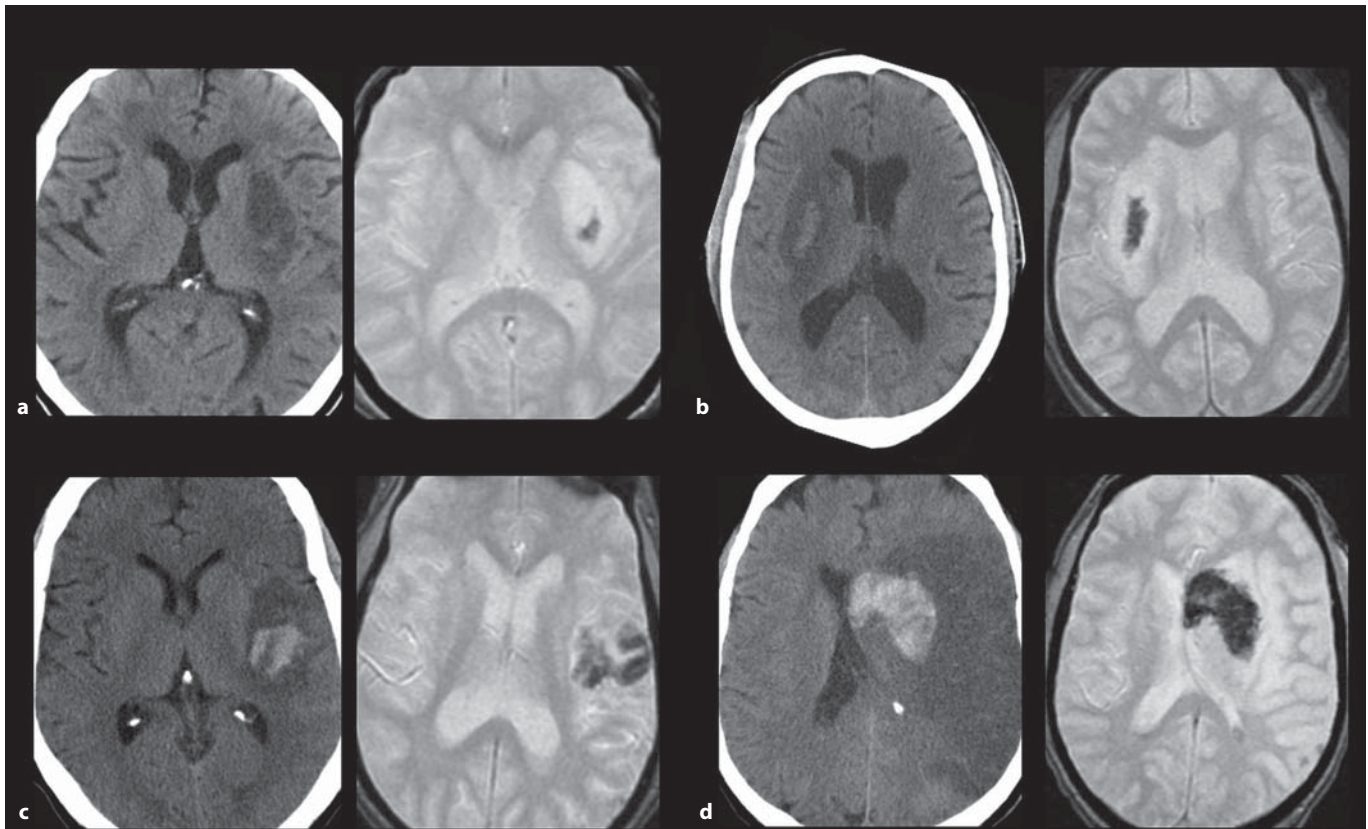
Ambiguous examples of bleeding categorization (CT image on the left, T2*GRE sequence on the right). a Distinction HI1/HI2: bleeding interpreted as HI1 on CT image and HI2 on T2*GRE sequence. b Distinction HI2/PH1: confluent petechiae interpreted as an HI2 but with space-occupying effect as a PH1. c Distinction HI2/PH1/PH2: parenchymal haematoma ~30% of the infarcted area as a PH1 or a PH2 but without any space-occupying effect like an HI2. d Distinction PH1/PH2: bleeding <30% of the infarcted area as a PH1 but with significant space-occupying effect like a PH2.
